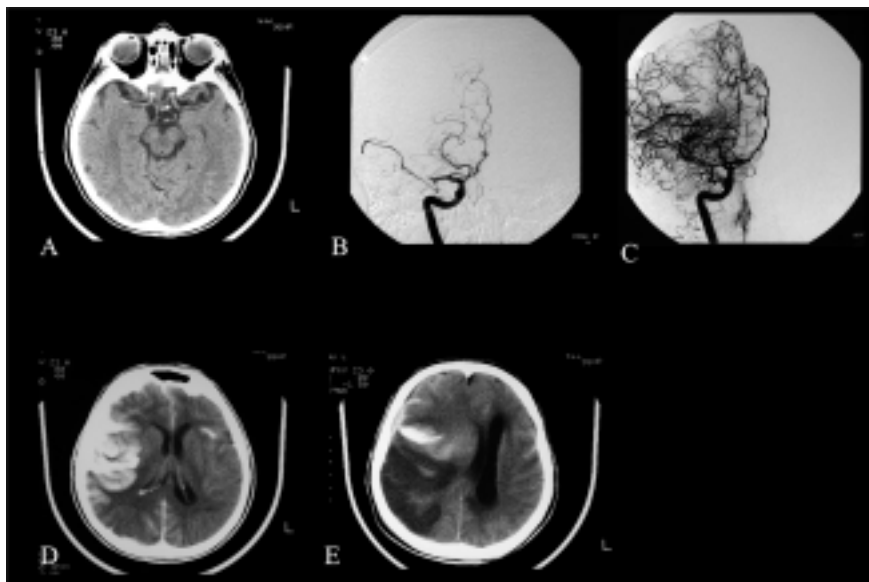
A: computed tomographic scan performed 1 day after the percutaneous coronary intervention immediately after a stroke with a left hemisyn-drome. There was no evidence of intracerebral bleeding. B: cerebral angiography performed 1 hour later, documenting thrombotic occlusion of the right mean cerebral artery. C: balloon angioplasty plus local fibrinolysis (urokinase 400 000 IU) was performed with reopening of a large part of the mean cerebral artery vascular bed. D and E: computed tomographic scans performed 1 and 3 days after. Evidence of massive cerebral damage and contralateral dislocation.
